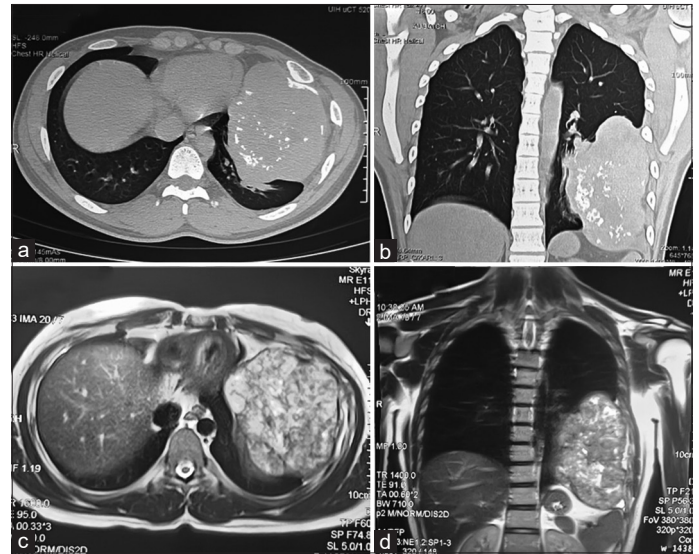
Cross-sectional imaging (a and b) is high-resolution computed tomography image showing well-defined large heterogenous hypodense lesions with coarse calcifications within eroding the cortex of the 6th rib; (c and d) is magnetic resonance imaging showing well-defined lobulated margins, hyperintense on T2-weighted/short-tau inversion recovery, with enhancing foci within (corresponds to calcifications on computed tomography)
